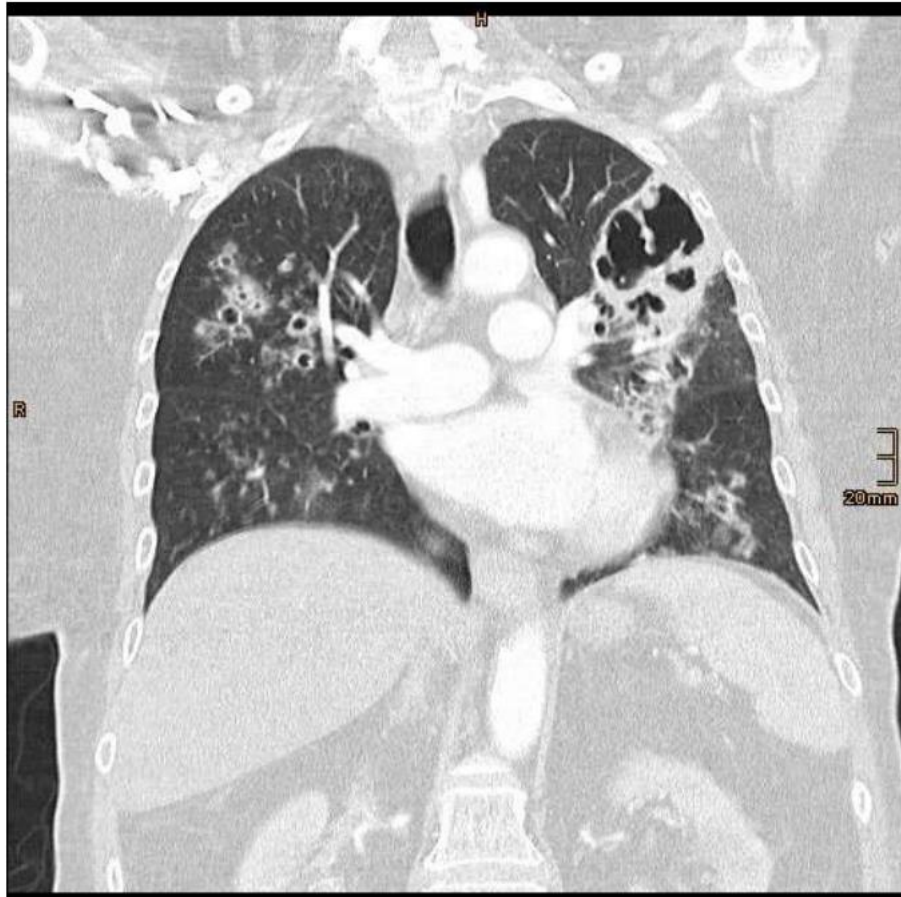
Chest CT ap., 8 days after admission.
